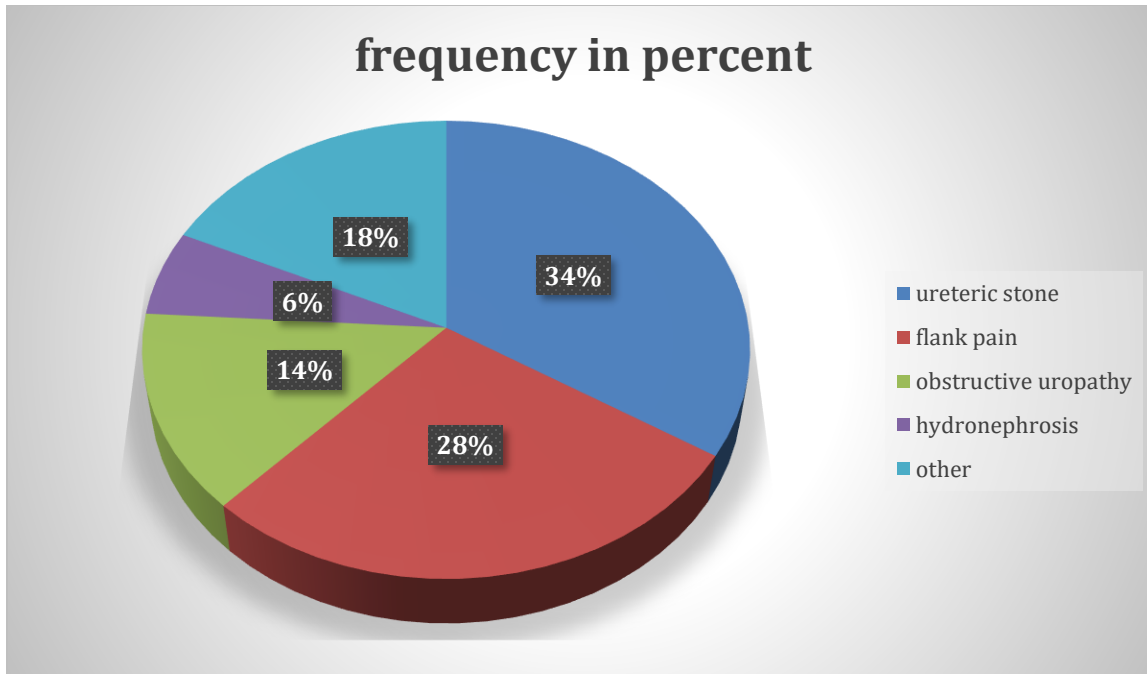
pie chart showing common indications for the CT scans done
